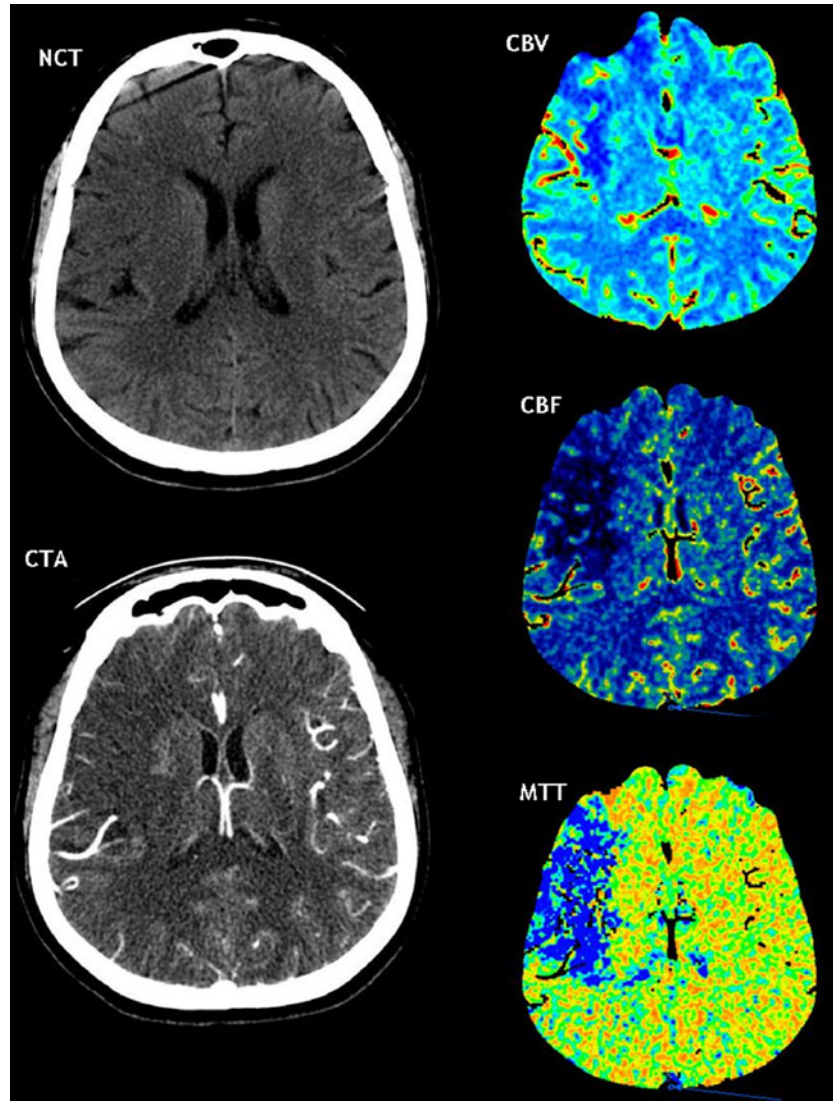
Multimodal CT imaging in a 63-year-old female patient with acute stroke obtained 4 h after symptom onset. NCT scan shows subtle loss of the gray–white matter interface in the right parietal lobe. CTA demonstrates a paucity of MCA distal branches in the affected brain area; no proximal MCA occlusion was found. PCT parametric maps show a nearly complete match between the MTT and CBV parametric maps. The patient was not treated with rt-PA. CTA = CT angiography; PCT = perfusion-CT; MTT = mean transit time; CBV = cerebral blood volume; rt-PA = recombinant tissue plasminogen activator. (High resolution version of this image is available in the [electronic supplementary material](#).)
